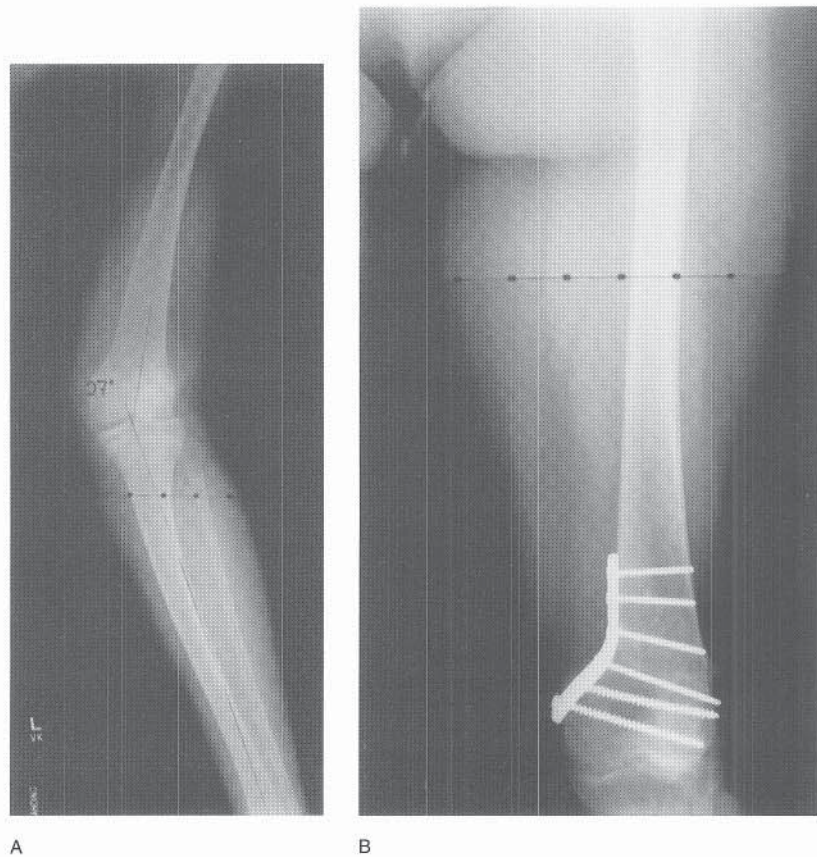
A, Radiographic appearance in a skeletally mature female with neglected genu valgum. Early lateral compartment degeneration was already present. B, Acute correction by closing-wedge osteotomy with medially placed internal fixation.
